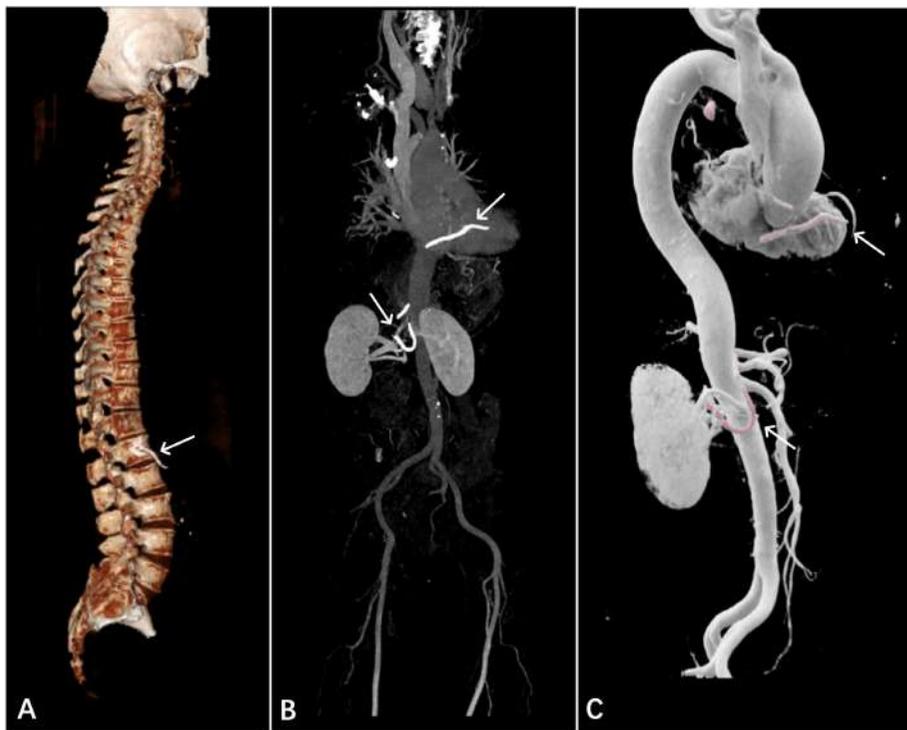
Contrast-enhanced CT with 3D reconstruction. Figure A shows a strip-like, fishbone-shaped bone cement fragment originating from the right anterolateral aspect of the T12 vertebral body. Figure B demonstrates the presence of bone cement adjacent to the T12 vertebra and within the heart. Figure C presents a 3D reconstruction of the fishbone-shaped bone cement fragment and its anatomical relationship to surrounding structures; the pink strip in the image represents the bone cement.
